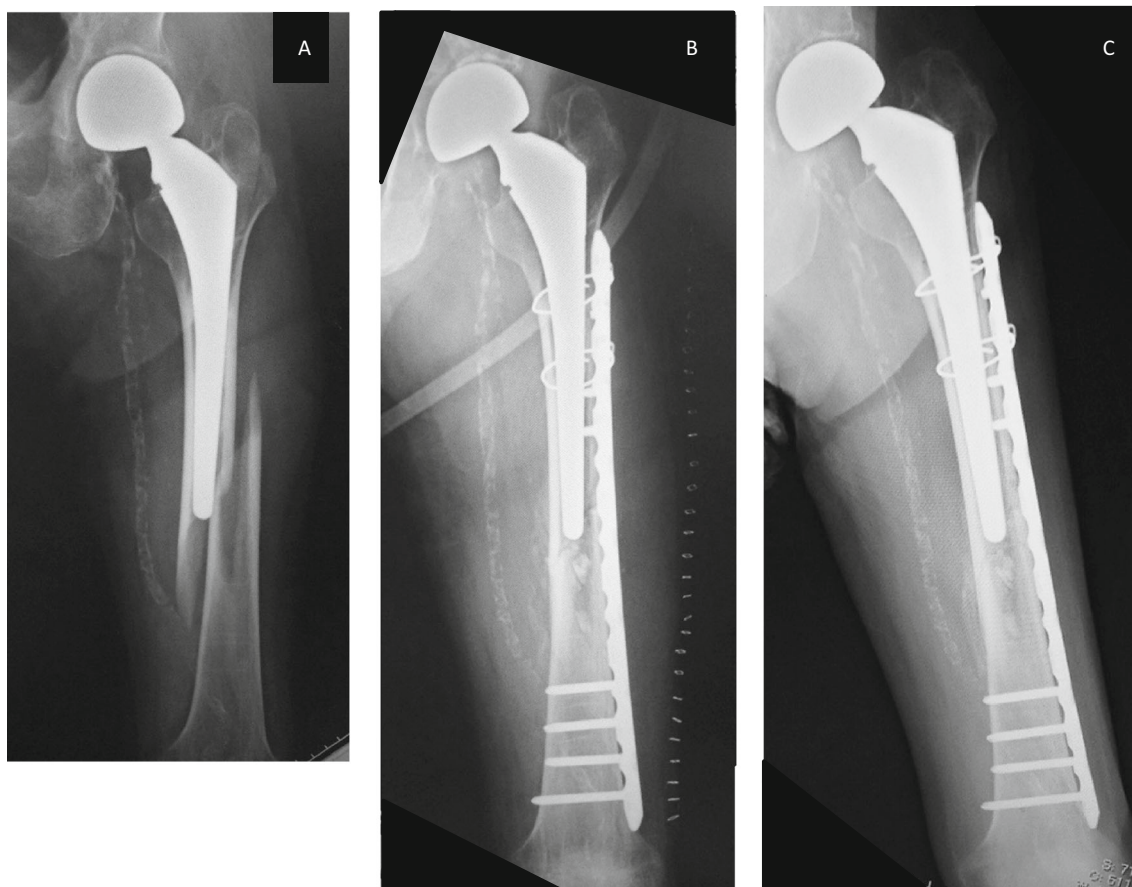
Seventy-four-year-old male. a X-ray radiography at the time of injury. Vancouver type B1 periprosthetic femoral fracture. b X-ray radiography immediately after surgery. Broad LCP was internally fixed. c X-ray radiography 6 months after surgery. Bone union was achieved
